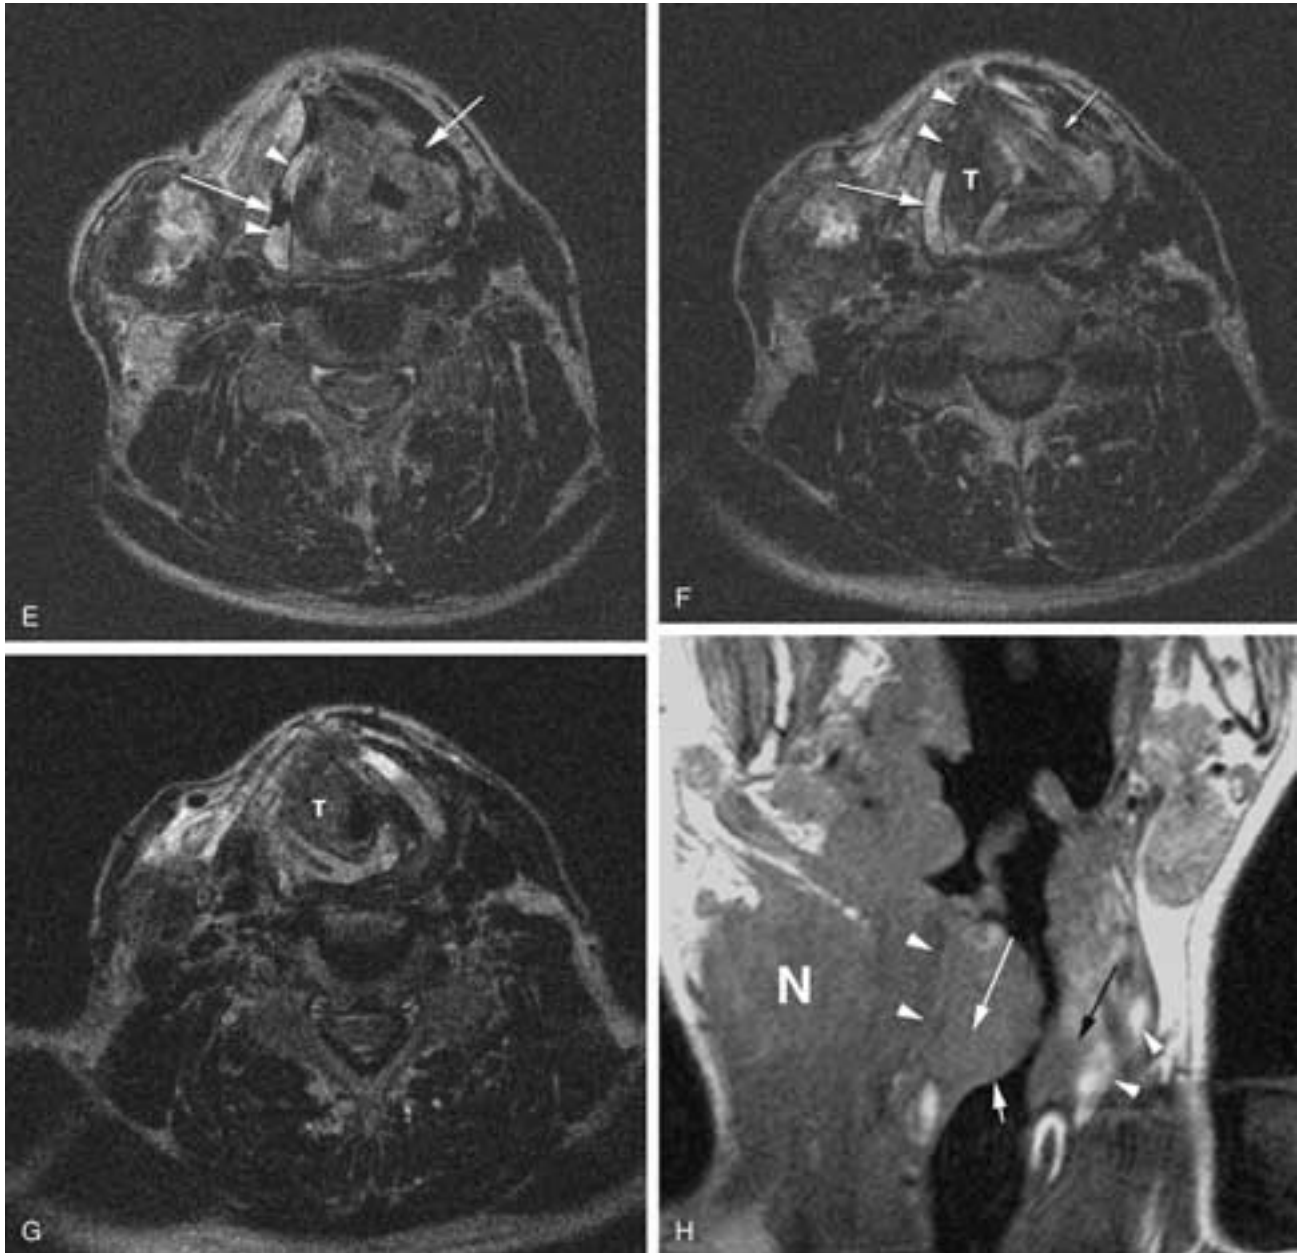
Continued.* E, Axial T2-weighted image, same level as A, level of the false cord. Note the bright signal in the abnormal portions of the cartilage (*arrowheads*) compared to the dark signal of nonossified cartilage (*arrows*). F, Same level as B. Tumor (*T*) fills the paraglottic region, producing fullness in the cord. The anterior part of the right ala of the cartilage (*arrowheads*) has low signal. The signal approximates that of the tumor and thus separation of tumor and nonossified cartilage is difficult. (Compare with the opposite side [*arrow*].) Posteriorly (*large arrow*) the signal is higher, reflecting edema within the cartilage. G, Axial T2-weighted image at the subglottic level shows the tumor (*T*) within the cricoid ring. H, Coronal T1-weighted image shows the tumor following the paraglottic pathway (*large white arrow*). Note the smooth margin of the true cord (*small white arrow*). The tumor is forced laterally toward the cricothyroid interval. Compare the low signal in the abnormal right cartilage to the bright signal of fat in the normal left thyroid cartilage (*arrowheads*). On the normal side, the black arrow indicates the upper edge of the thyroarytenoid muscle, thus indicating the level of the ventricle. *N*, Metastatic node.
